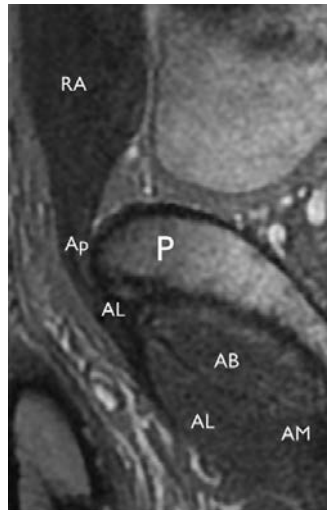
A MRI image taken in the sagittal plane showing the continuation of Rectus Abdominis (RA) with Adductor Longus (AL) over the Pubis (P). Ap recognises the aponeurosis, Pesquer et al (2015).
